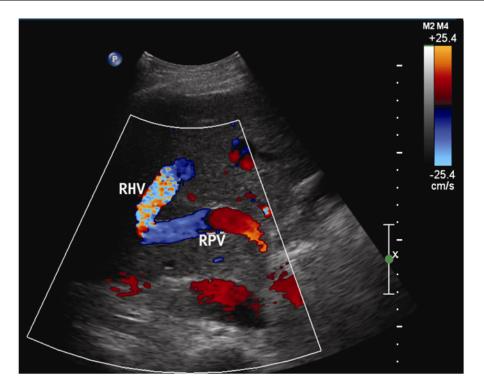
Doppler ultrasound demonstrated marked dilatation of the right hepatic vein with increased pulsatility in the right and middle hepatic veins.
